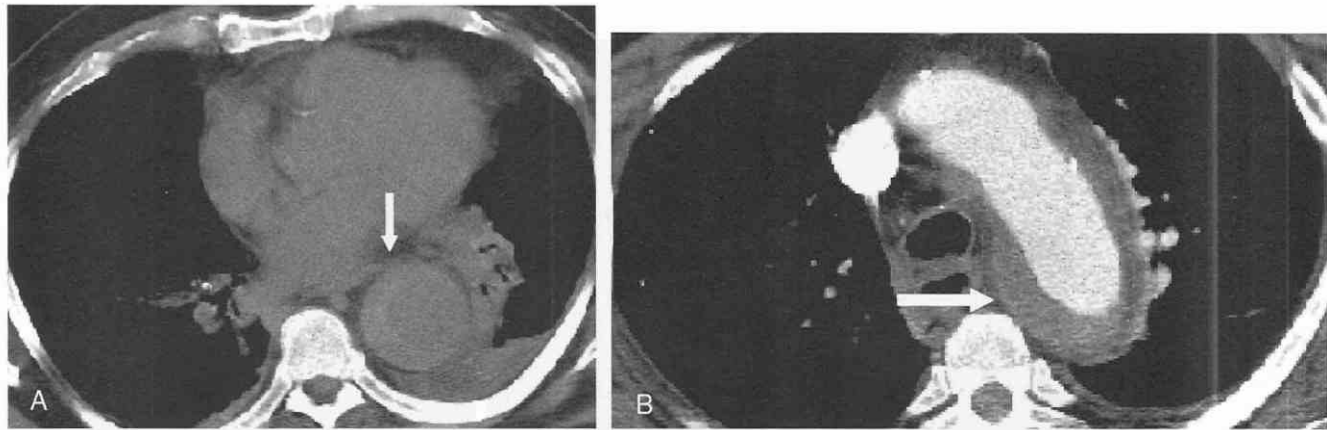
A, Axial noncontrast CT scan shows a rim of high attenuation of the aortic wall (arrow) in a patient with acute chest pain. B, Axial CT scan after administration of a contrast agent demonstrates diffuse periaortic soft tissue with high attenuation (arrow), a feature consistent with acute intramural hematoma.
